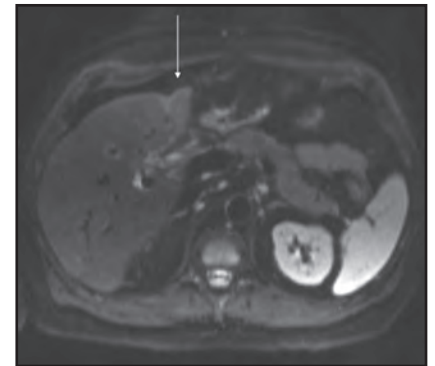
First post-IRE/SBRT MRI scan demonstrating left lobe atrophy (arrow).
